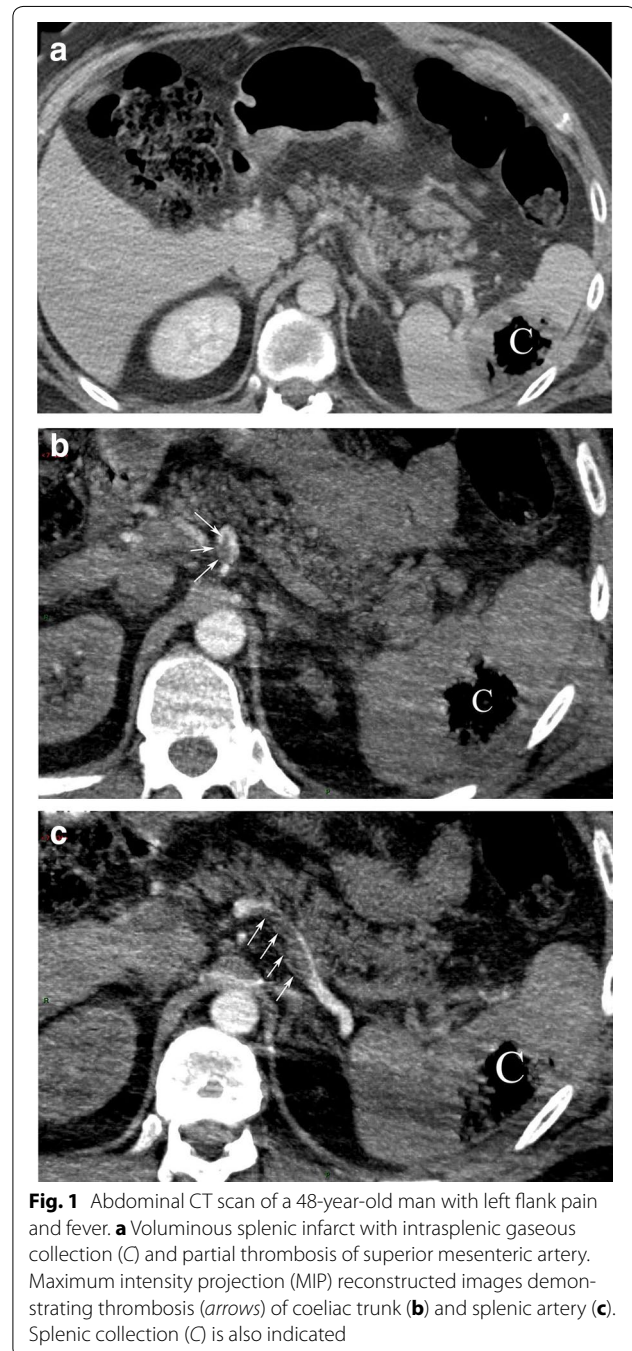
Abdominal CT scan of a 48-year-old man with left flank pain and fever. a Voluminous splenic infarct with intrasplenic gaseous collection (C) and partial thrombosis of superior mesenteric artery. Maximum intensity projection (MIP) reconstructed images demonstrating thrombosis (arrows) of coeliac trunk (b) and splenic artery (c). Splenic collection (C) is also indicated
